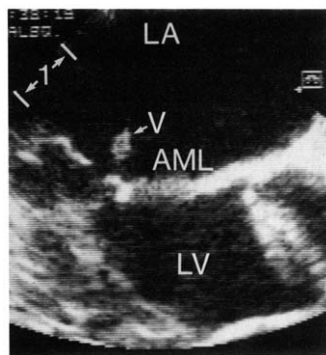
Small mitral vegetation. The transesophageal image plane is tangential to the mitral annulus, showing a truncated view of the left ventricle (LV). A small mass (V) is tethered from the tip of the anterior mitral leaflet (AML) and prolapses into the left atrium (LA). In real time, this mass showed rotatory motion independent of the leaflet. A 1-cm distance is indicated diagonally to the left.
